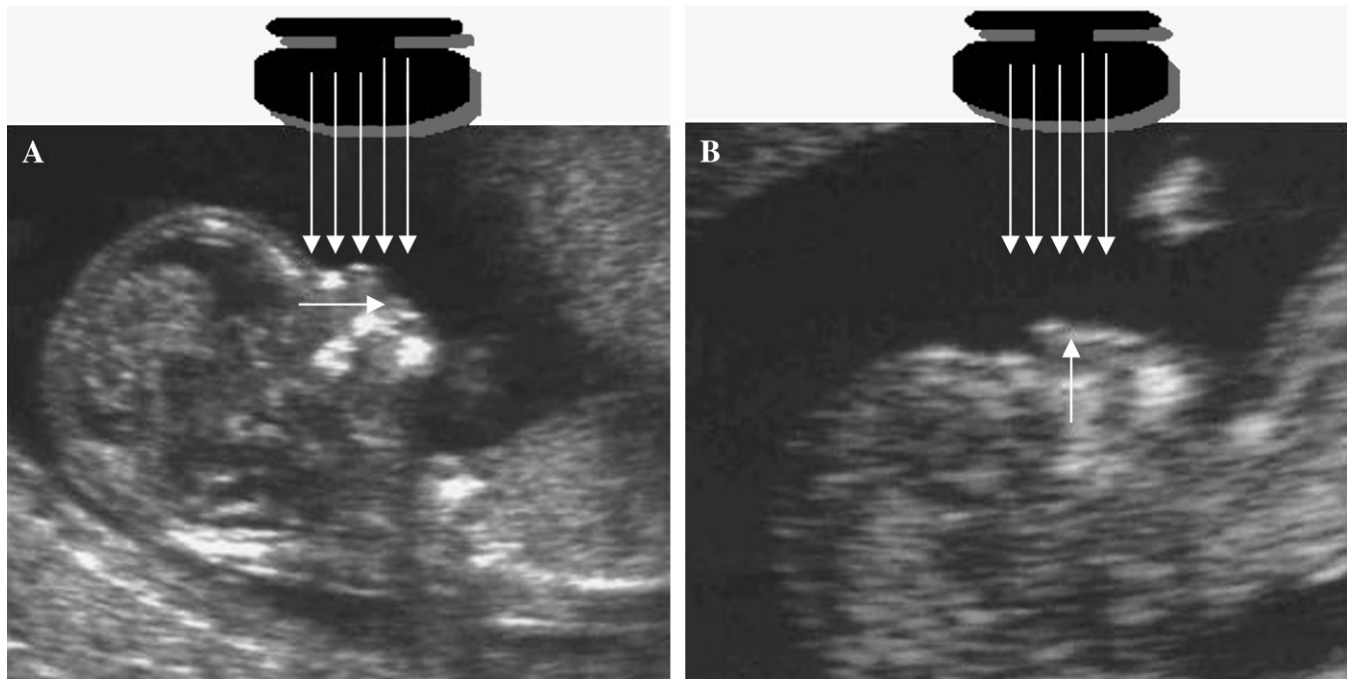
A, Correct angle of insonation (90 degrees) for detection of the nasal bone. B, The nasal bone is artificially absent because of a wrong angle of insonation (180 degrees). Reprinted with permission from Cicero S, Dezerega V, Andrade E, Scheier M, Nicolaides H. Learning curve for sonographic examination of the fetal nasal bone at 11-14 weeks. *Ultrasound Obstet Gynecol* 2003;22:135-7.
